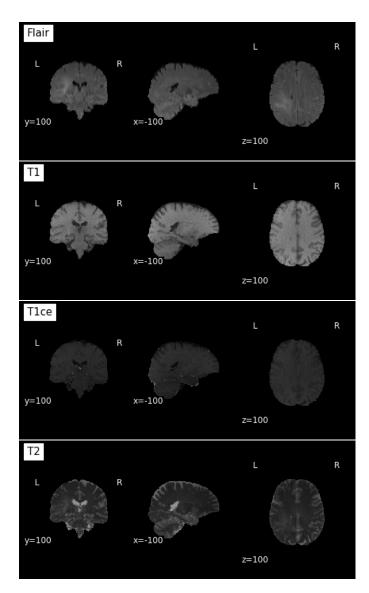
FLAIR, T1w, T1wCE, T2w Scans respectively
